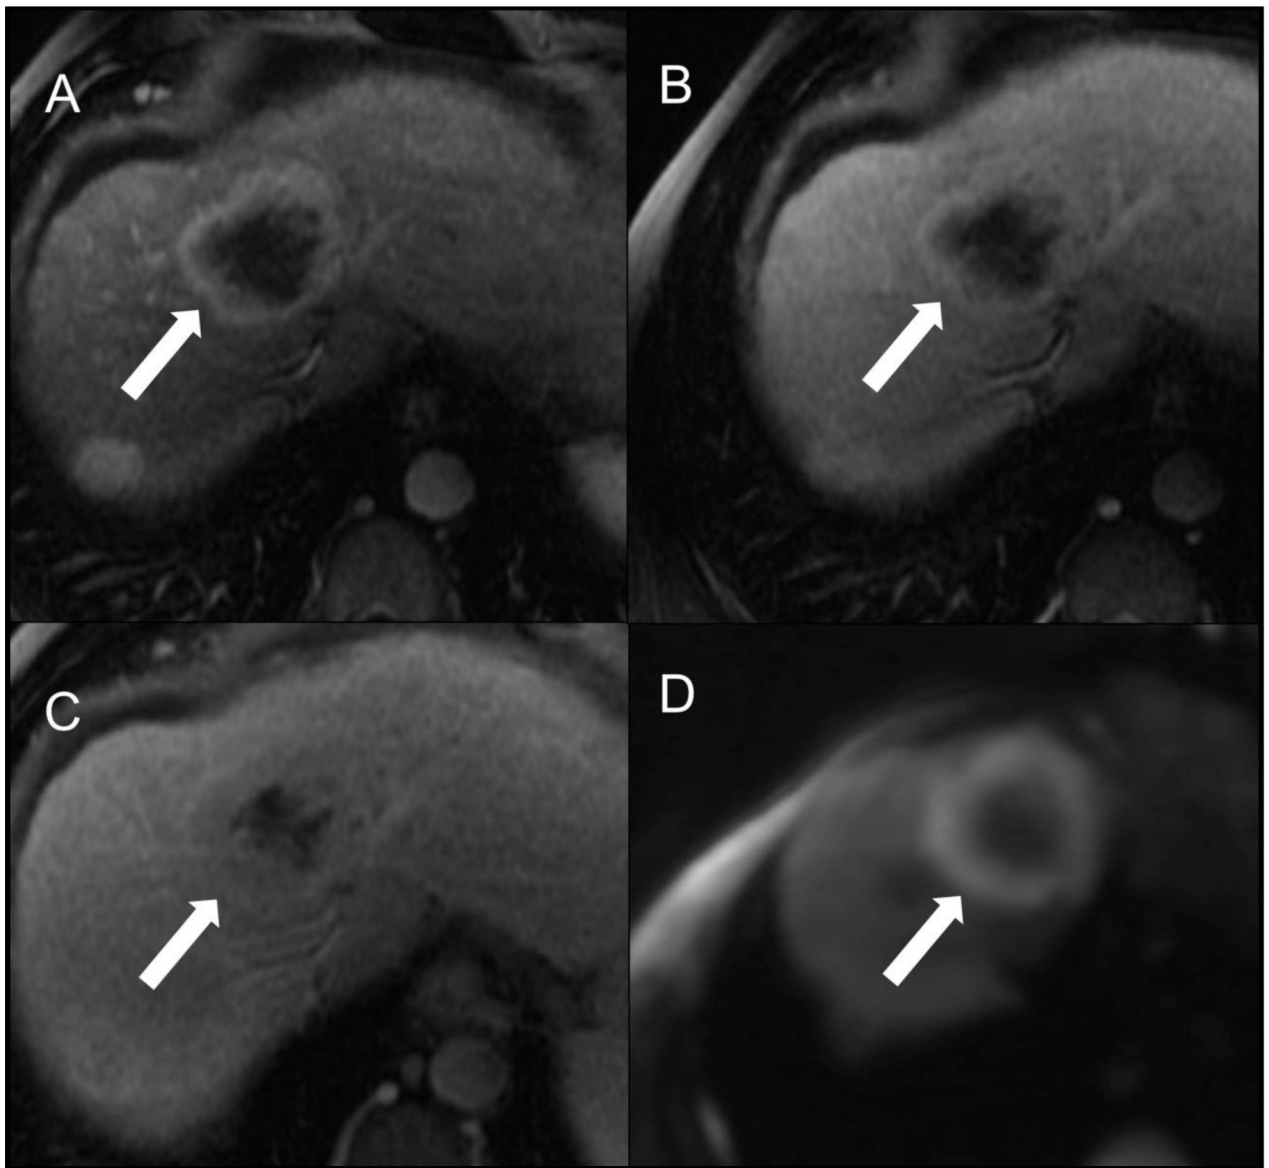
Representative cHCC-CCA scored as LR-M by both readers. Patient is a 63-year-old male with alcoholic cirrhosis undergoing MR examination following an ultrasound screening examination revealing a segment 8 intrahepatic lesion (not shown). Arterial (A), portal venous (B), delayed (C) post-contrast sequences and diffuse-weighted imaging (D) after gadobenate dimeglumine (MultiHance) administration demonstrate a segment 8 observation measuring approximately 6 cm in size (arrows). Both study readers agreed on the presence of targetoid appearance (including targetoid restriction) and rim APHE. R1 categorized the lesion as having peripheral “washout” and a necrotic appearance whereas R2 did not; R2 categorized the lesion as having delayed central enhancement whereas R1 did not. Both readers categorized this observation as LR-M using LI-RADS v2017 and v2018.
